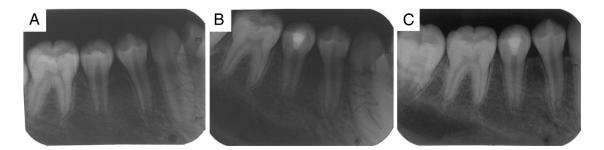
(A) The preoperative radiograph of tooth #29. (B) The postoperative radiograph at the 3-month recall. (C) The postoperative radiograph at the 12-month recall.
